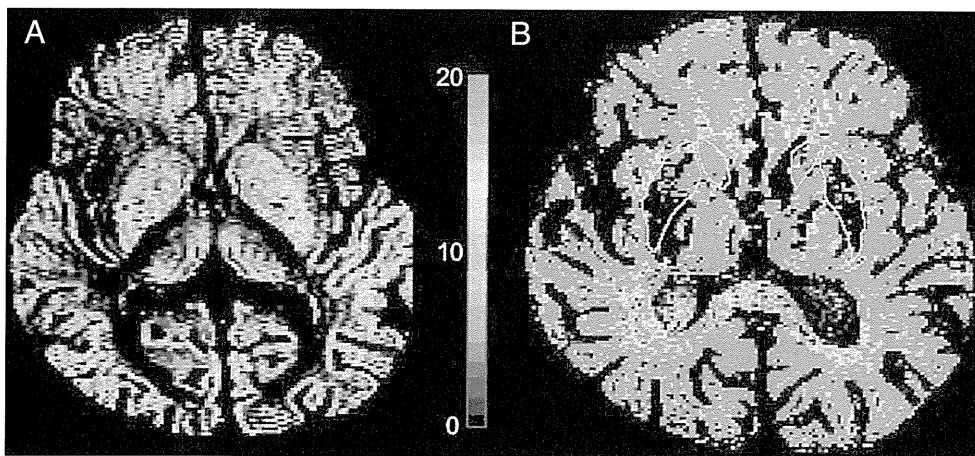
Iron mapping of the brain using a 4.7 Tesla MRI T_2^* scan. The colored bar indicates the iron content in mg/100 g fresh weight of the brain. In the healthy brain, a high level of iron was seen only in the globus pallidus. In almost all regions in the patient's brain, the iron level exceeded 20 mg/100 g fresh weight. In the basal ganglia, voids were seen due to too short T_2^* caused by the very high iron accumulation, over 60 mg/100 g fresh weight. (a) A 60-year-old healthy male; (b) a 60-year-old male suffering from anemia, retinal degeneration and diabetes with insulin treatment, who had experienced gait ataxia for 5 years.
